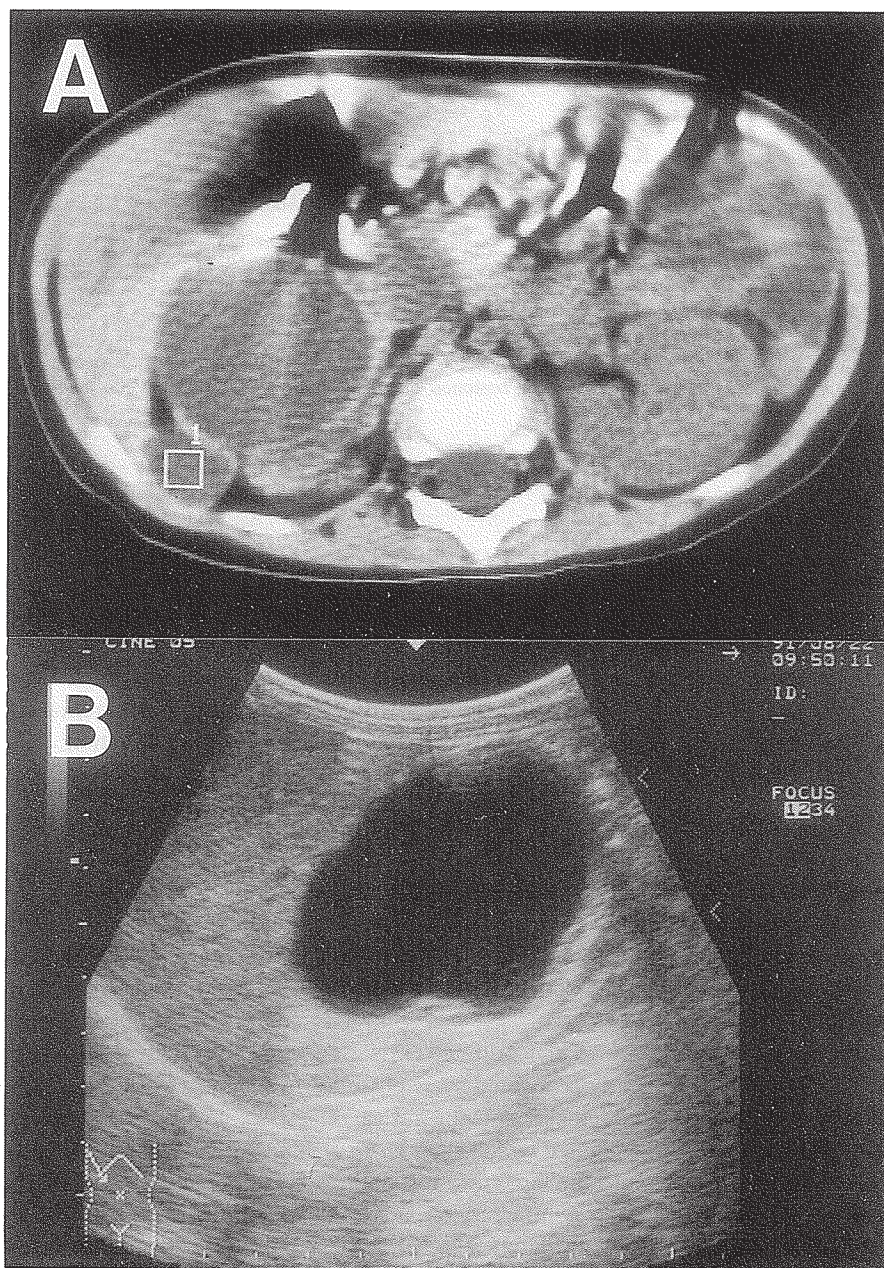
Computed tomography (A) and ultrasonography (B) at the age of one year show several cysts and a mass in the right renal fossa.
